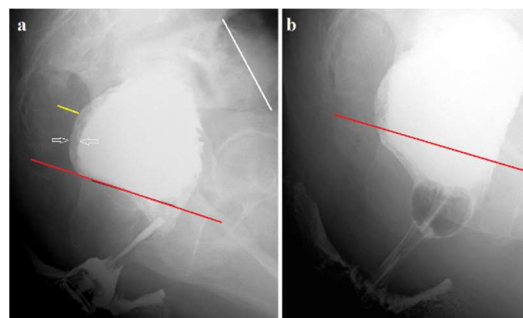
The study was carried out after colon cleansing. (a) A lateral radiograph of the anorectum was taken after administration of 300 ml of barium. It is known that the true length of the anal canal between the anus and the pubococcygeal line (red) in adults is ≈ 4 cm. The rectum is only partially filled, as evidenced by the expanded retrorectal space (yellow line) as well as traces of barium in the folds of the mucosa between the white arrows. The presence of barium below the p-c line indicates insufficiency of the puborectalis muscle (descending
